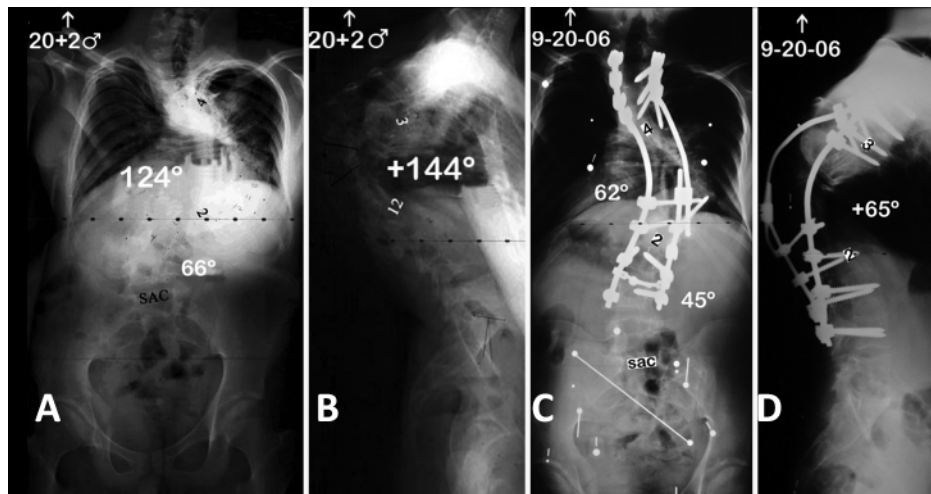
Case 3. Preoperative standing anteroposterior (A), preoperative standing lateral (B), postoperative standing anteroposterior (C), and postoperative standing lateral (D) 36-inch radiographs. A 2-level VCR enabled profound correction of a very severe kyphoscoliosis. sac = sacrum.
